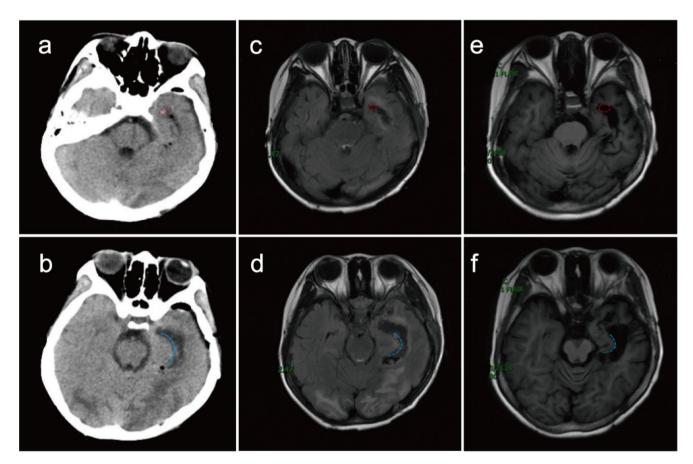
Images of case 2 (a) and (b) Axial CT on the first day after surgery showed that the amygdala was aspirated (red circle) and the medial temporal lobe structures were severed (blue line) and no obvious bleeding was observed. (c) and (d) Axial MRI in one week after surgery showed that the amygdala was sucked out (red circle) and the connection between the hippocampus and temporal cortex was severed
